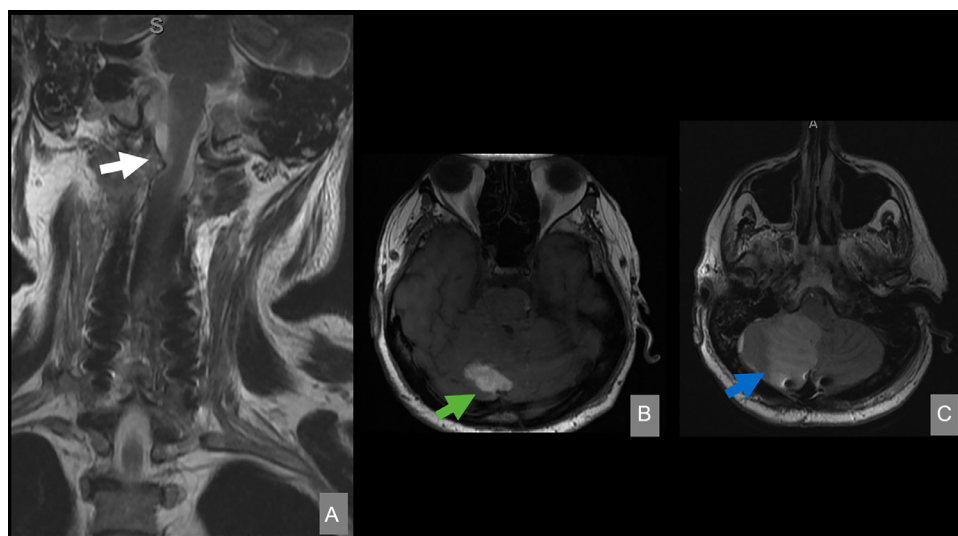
(A) MRI coronal view showing an epidural hematoma at the C2 level (white arrow). (B and C) MRI axial view demonstrating a cortico-subcortical swelling zone (blue arrow) that impacts the posterior and inferior aspects of the right cerebellar hemisphere. A hematoma (green arrow) measuring 3.3 × 1.7 cm is observed, contributing to the compression of the fourth ventricle.
